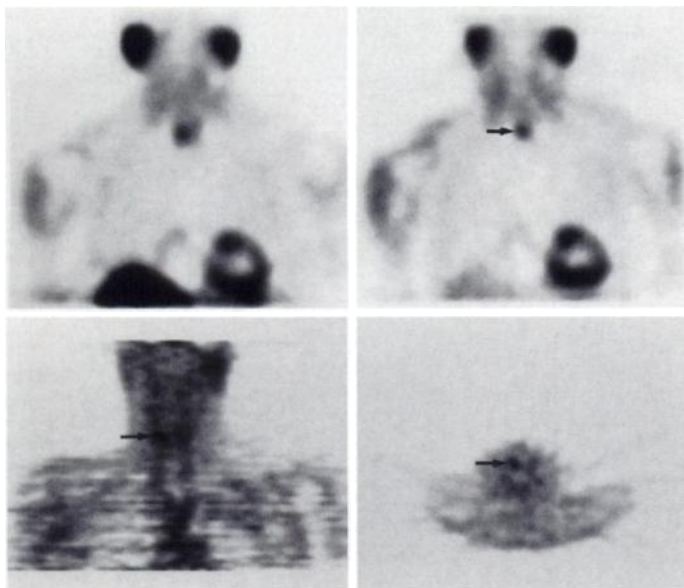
Concordant image results. A 722-mg parathyroid adenoma was found at surgery in the right lower neck. Sestamibi-SPECT shows preferential retention of activity in the right lower neck (arrows) on (A) coronal early and (B) delayed tomograms. FDG-PET shows increased uptake (arrows) in the right lower neck on (C) coronal and (D) transverse tomograms.
